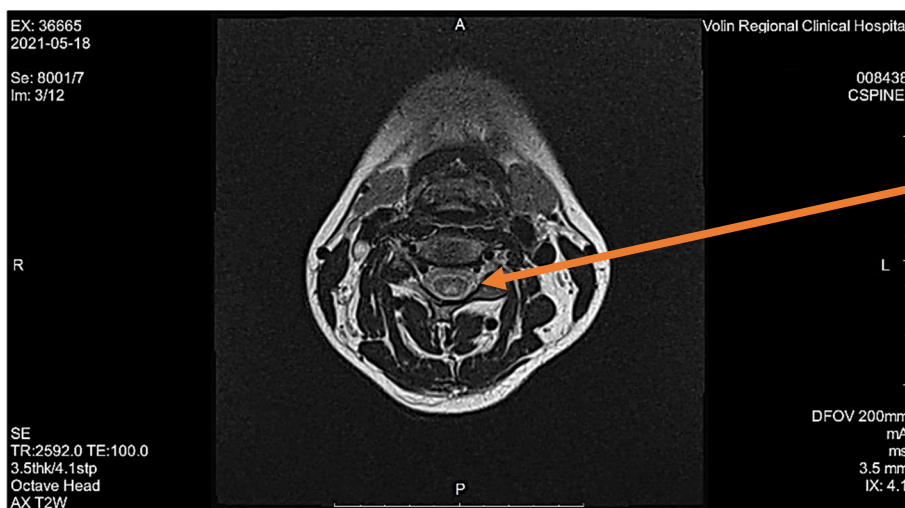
Magnetic resonance imaging of the cervical spine on May 18, 2021, axial plane, T2 sequence. Hyperintensity in the posterior cords of the spinal cord (arrow)
